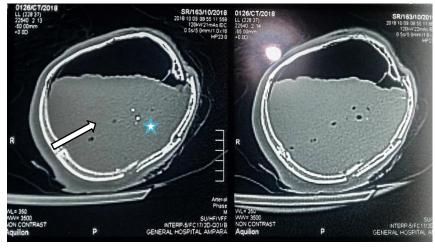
4. CT of the head [*The section is at the level of vertex in this figure. The position of the head is turned on to the left. There is a pathway of pneumocephalus (arrow) along with two metal pieces (*)].*
